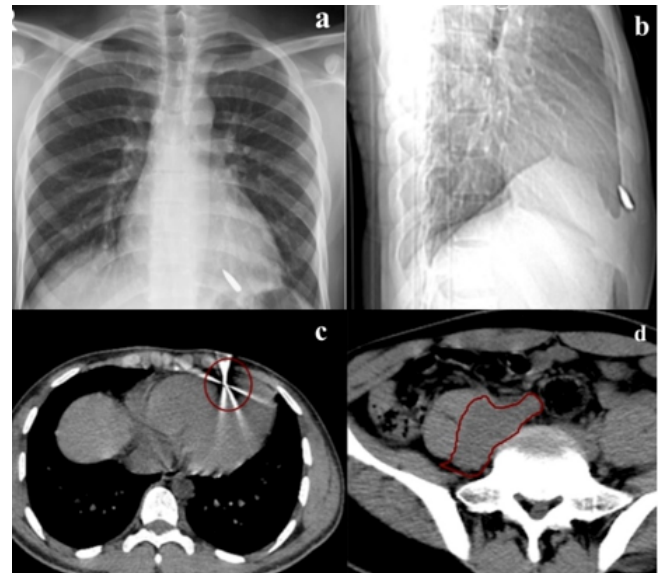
Posterior-anterior and b. lateral chest X-ray showing the bullet core in the left anterior hemithorax, c. thorax CT showing metal reflection close to the left ventricle and d. abdominal CT showing a 25×45 mm sized abscess right iliopsoas muscle.
